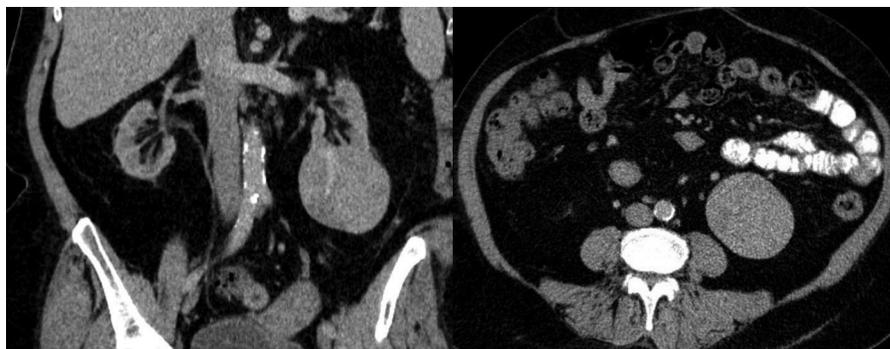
Contrast enhanced CT: 70x59 mm lesion with the same enhancement and wash-out as the renal parenchyma, proving a benign pattern.
